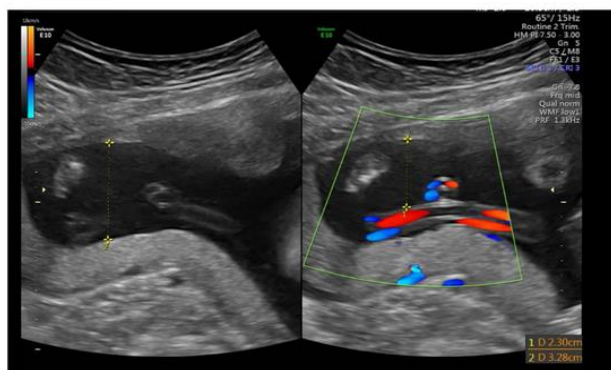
Example A of the evaluation of the volume of amniotic fluid by utilizing color Doppler on the R side of the screen and gray scale on the L side of the screen for determining the amniotic fluid pocket.
